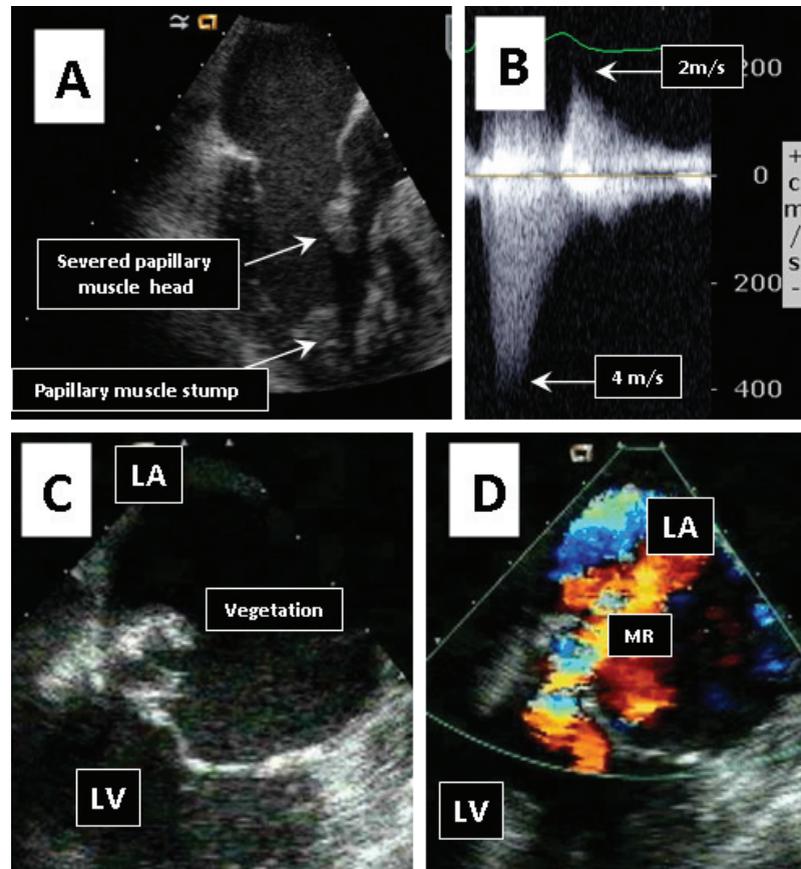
Mitral regurgitation. Panel A demonstrates anterior papillary muscle rupture in a patient with recent myocardial infarction. Panel B shows spectral Doppler tracing in a patient with severe acute mitral regurgitation. Note the relatively low peak velocity of the mitral regurgitant jet (4 m per second in this patient compared with approximately 5 m per second in normal people) indicative of systemic hypotension. The jet also decelerates rapidly towards the baseline indicative of rapid equilibration between LV and LA pressures toward the end of systole. Note also the relatively high antegrade velocity (2 m per second in this patient; normal is approximately 1 m per second) indicative of severe mitral regurgitation and a large regurgitant volume. Panels C and D show transesophageal echocardiographic findings in a patient with *Staphylococcus aureus* mitral valve endocarditis. Panel C is a 2D image showing large vegetation on the atrial side of the anterior mitral leaflet. Panel D demonstrates a very large regurgitant jet originating from the perforated anterior mitral leaflet. LA, left atrium; LV, left ventricle; MR, mitral regurgitation.
